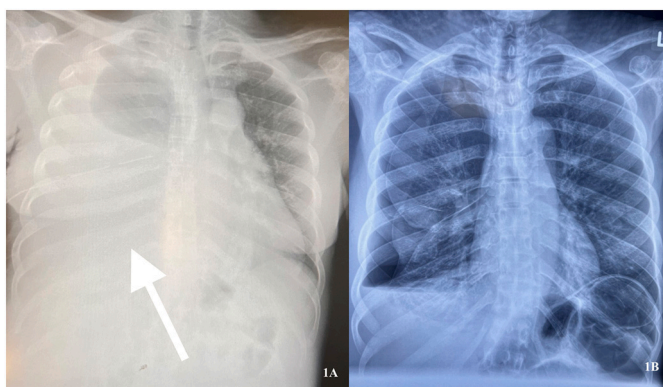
Chest radiographs: (1A) Erect chest X-ray demonstrates massive right-sided pleural effusion extending to the apex of the right lung. (1B) Erect chest X-ray demonstrates 85% resolution of hemothorax following thoracentesis and initiation of hormonal therapy.
